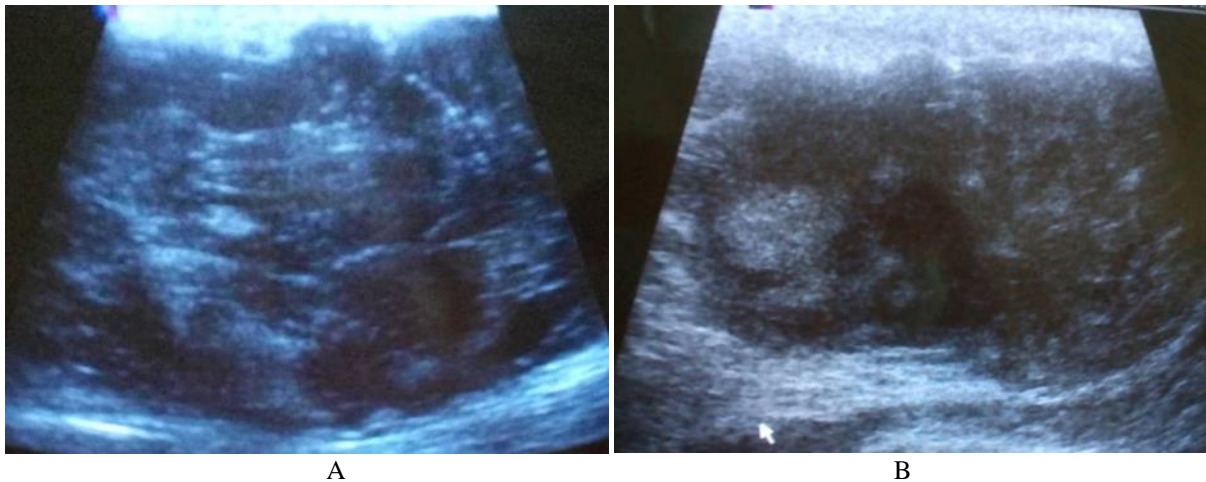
Ultrasound sections showing a heterogeneous hypodense mass with an area of internal necrosis (A=right breast, B=left breast)
